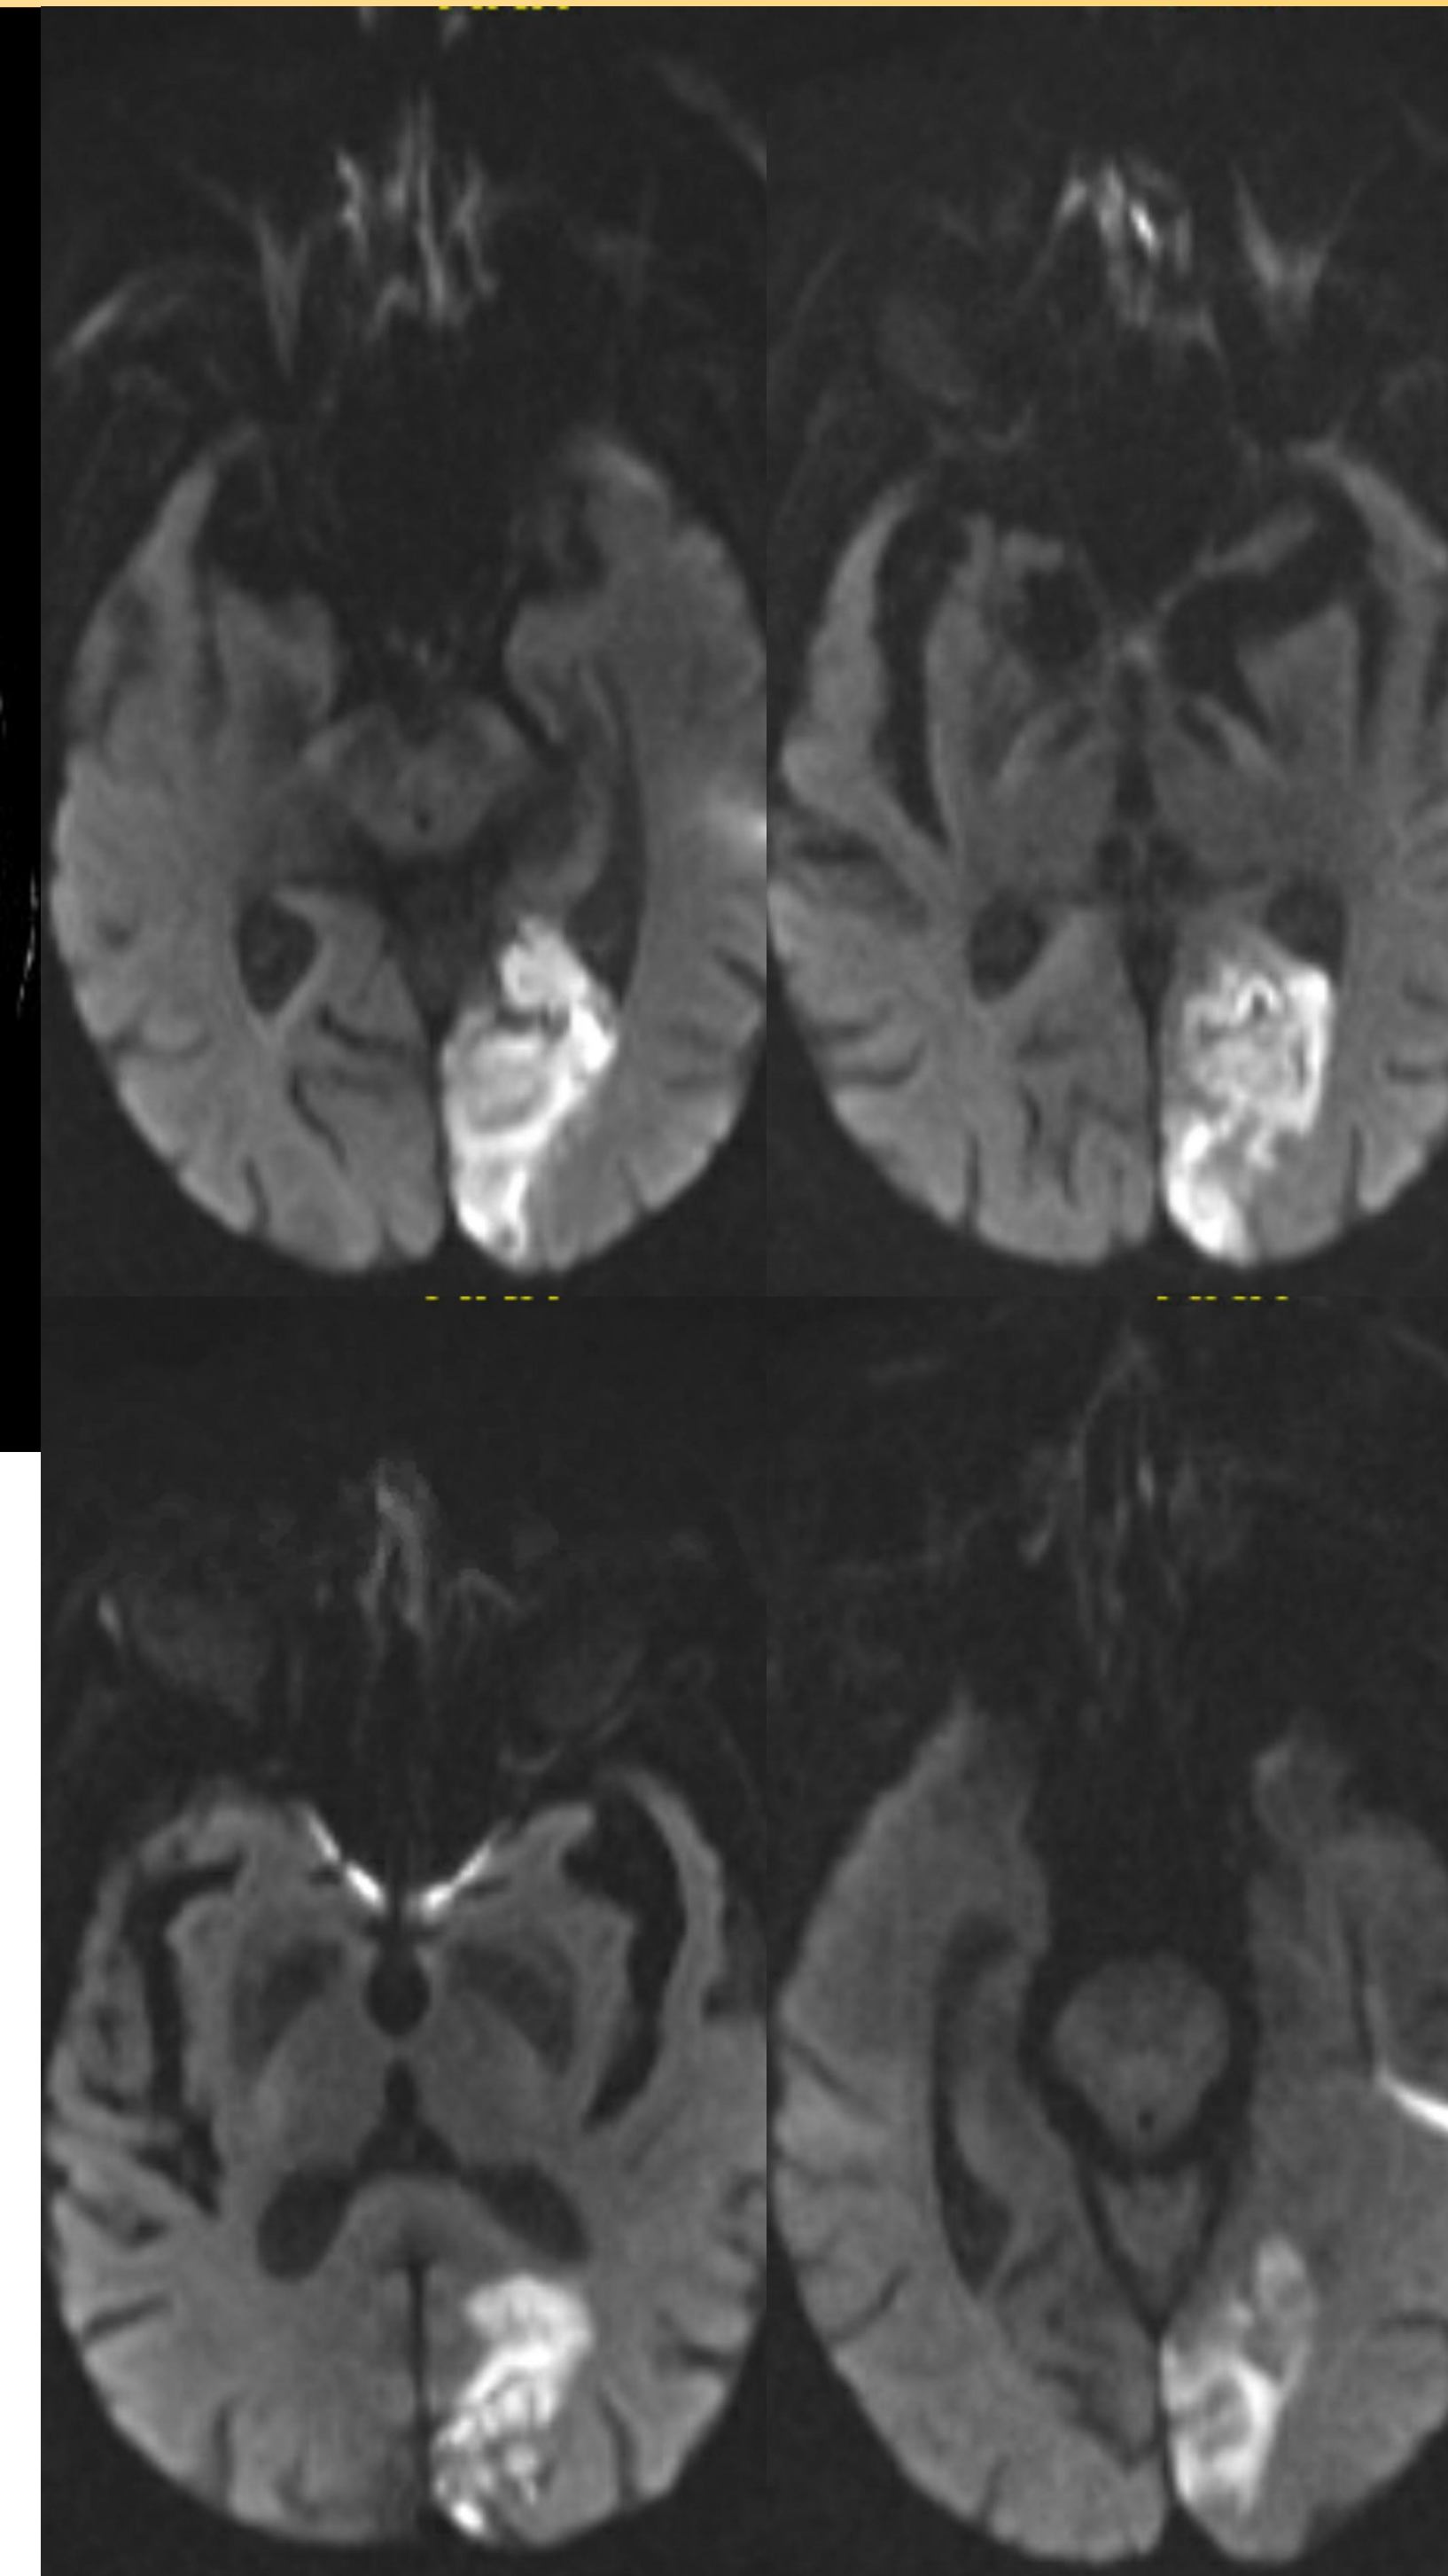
Patient's MRI head imaging showing subacute L occipital lobe infarct
